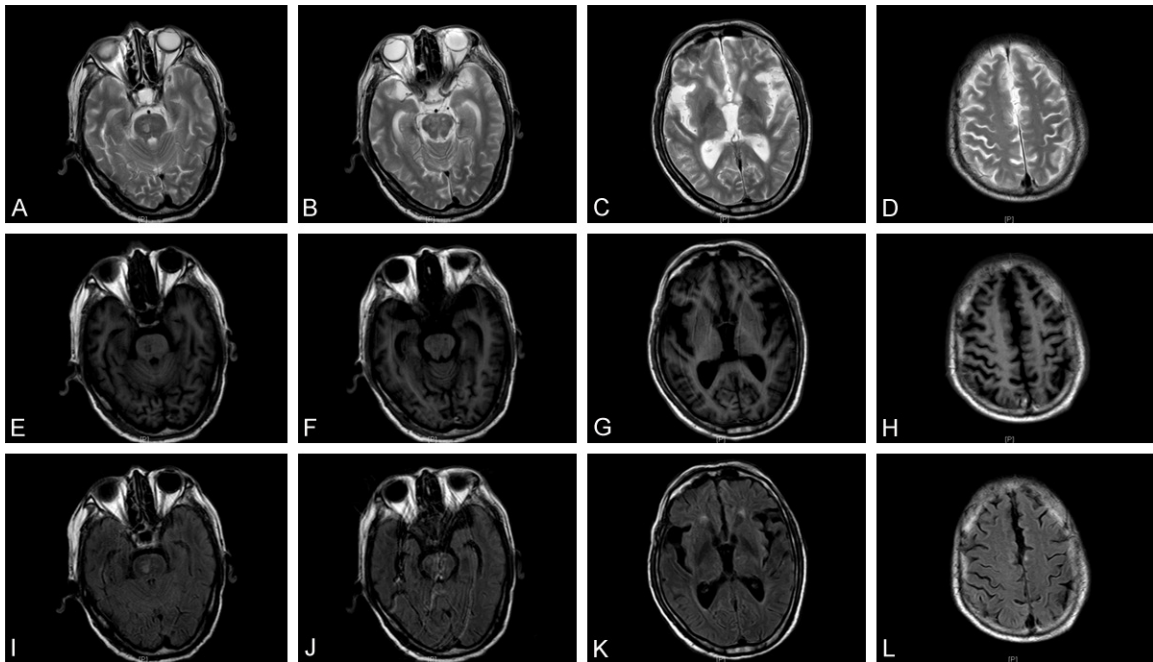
The MRI of cranium shows that there are multiple patching or dot abnormal signals of long T1 (E-H) and T2 (A-D) of the right cerebellar hemisphere and the brain stem, especially in Flair (I-L). And there are small amounts of patching abnormal signals of long T1 and T2 of bilateral basal ganglia, corona radiata and centrum ovale, especially in Flair. The rest parenchyma shows no abnormal signal, while the cistern and the sulcus widen and the cerebral ventricles over the tentorium enlarge. The median structure doesn't deflect.
